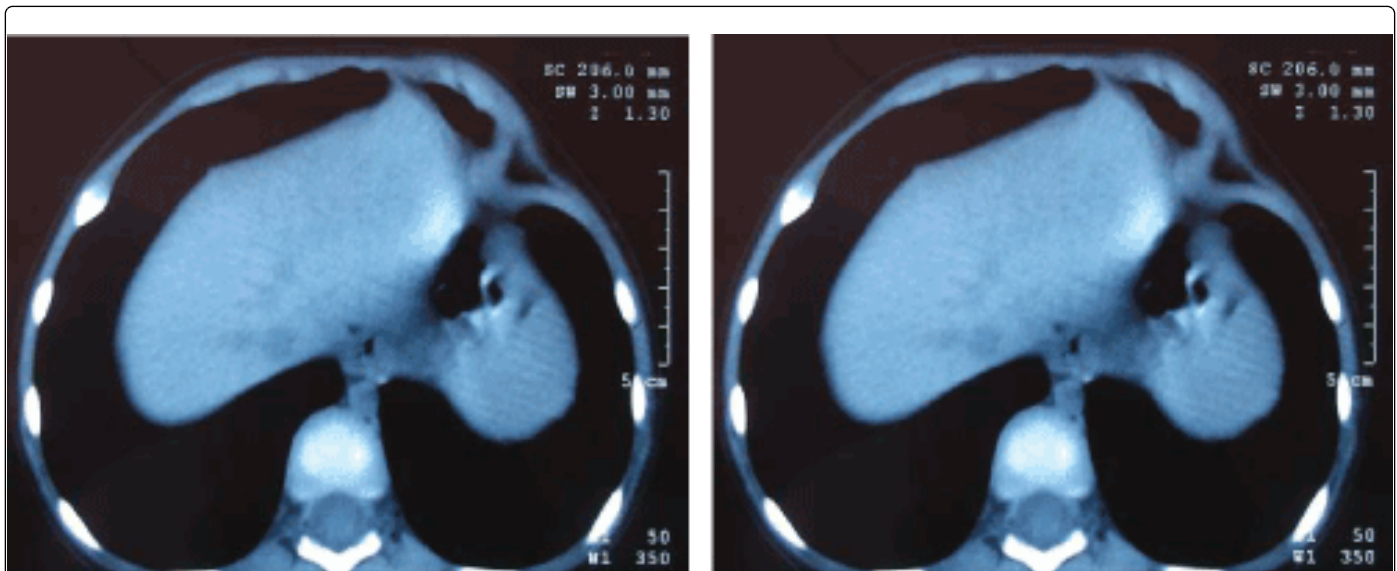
Abdominal CT scan.
